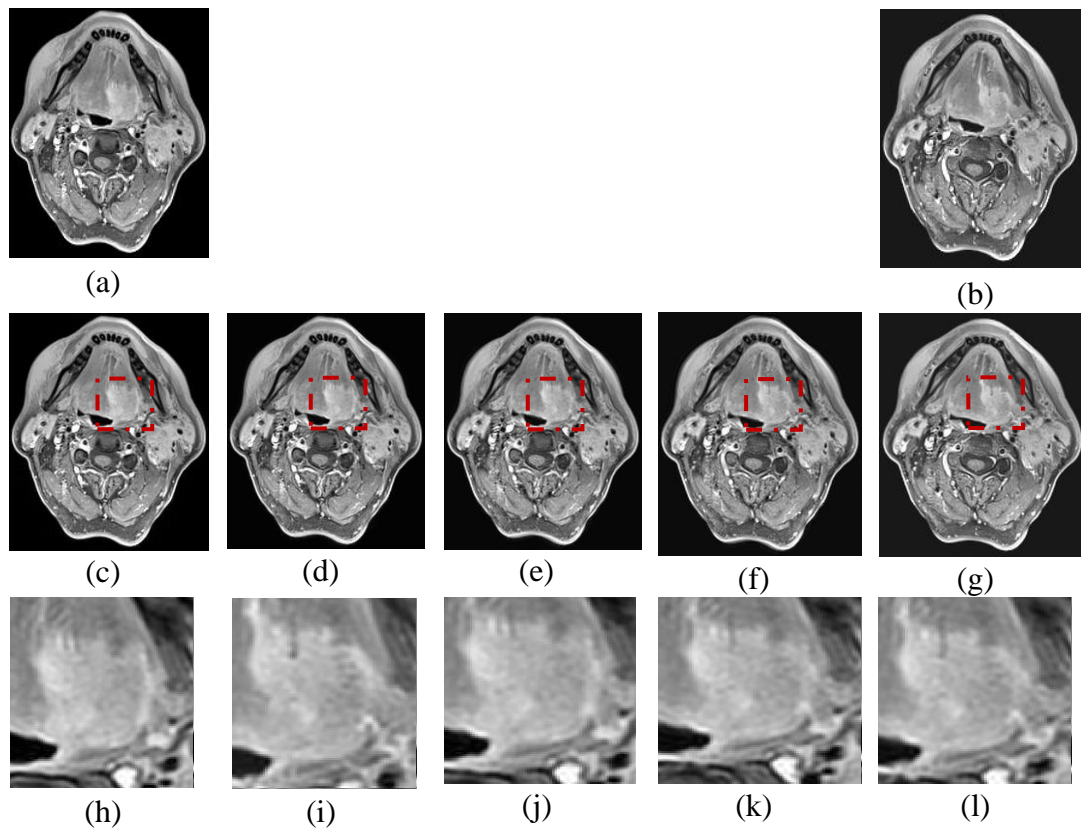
(a)(b) two consecutive MRI slice before interpolation. (c-g) are two slices after interpolation and three synthetic slices generated in interpolation. Red dash boxes mark the rough tumour position. (h-l) The zoomed tumour region after interpolation.
